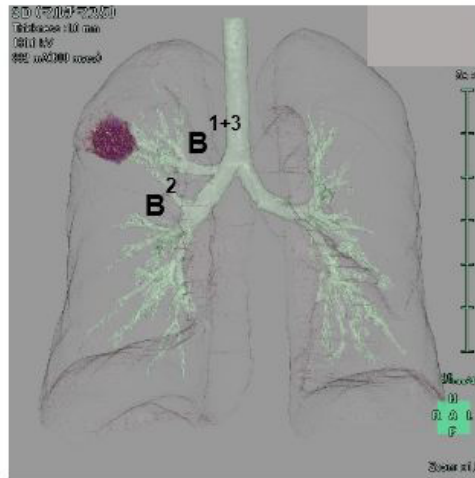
3D-CT The right B1+3 branching from the orifice of the right main bronchus and the right B2 branching from the intermediate bronchus.
